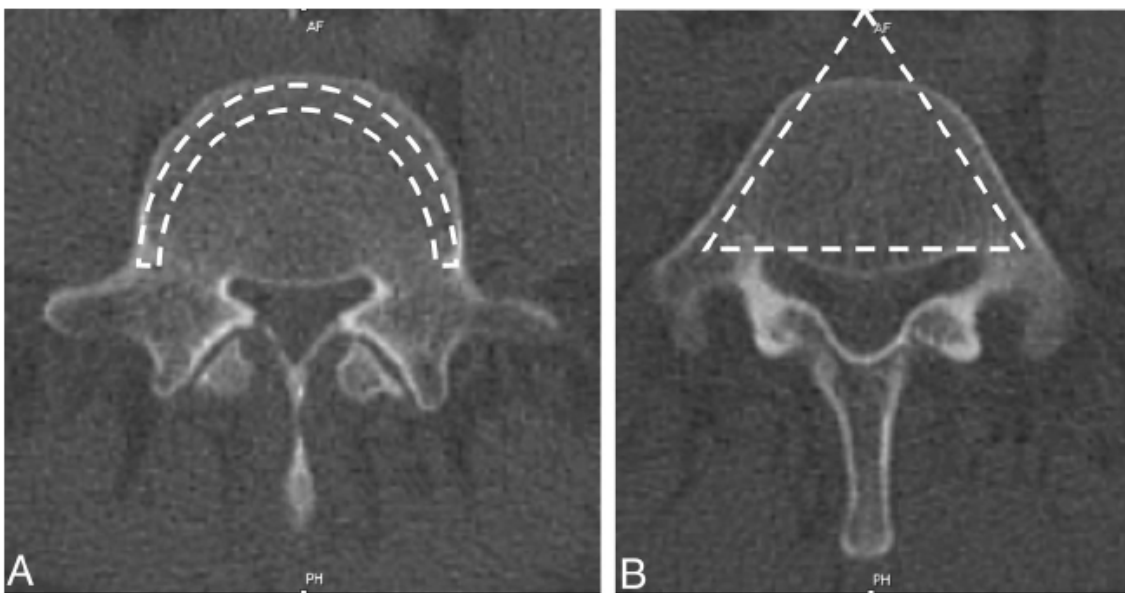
A, Hemispherical shape of L5 in a CT slice in the upper part of the pedicle. B, Triangular shape of L5 in a CT slice in the lower part of the pedicle.
